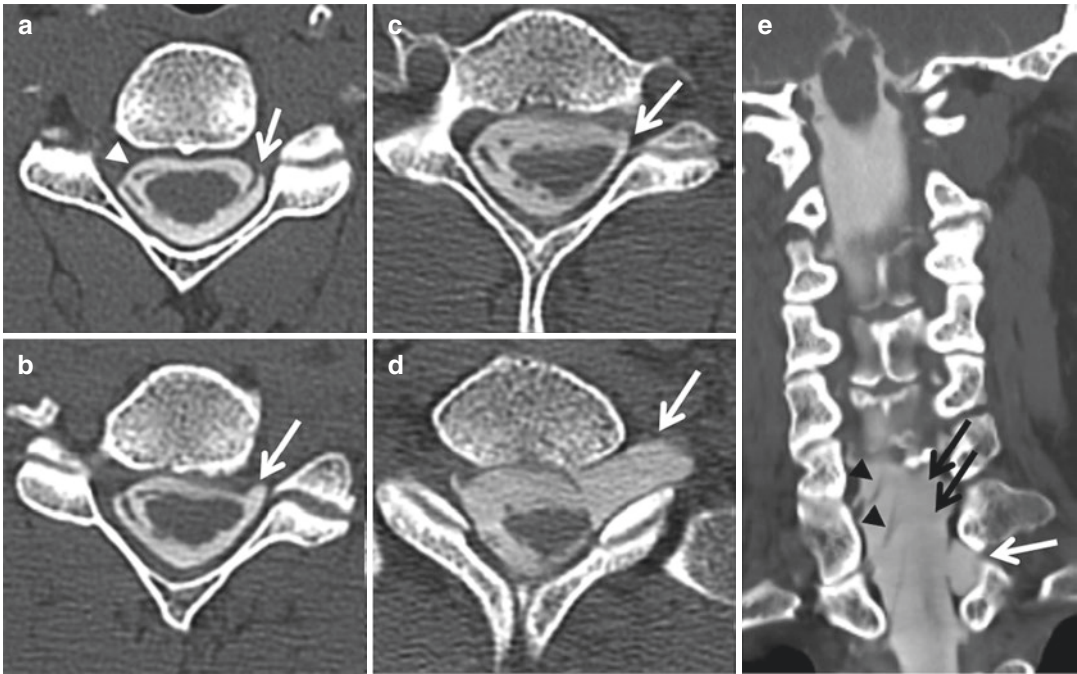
Partial and complete nerve root avulsions and a pseudomeningocele. Axial (a–d) and coronal (e) CT myelography images. At C4–5 (a), a partial left C5 nerve root avulsion is present, with nonvisualization of the left ventral nerve root (compared to normal right (arrow-head)); the left dorsal root is intact (arrow). At C5–6 (b) and C6–7 (c), complete left C6 and C7 nerve root avulsions are demonstrated, respectively, with nonvisualization of both the ventral and dorsal nerve roots (arrows)
